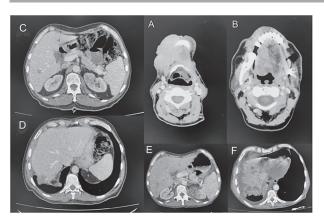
Computed tomography (CT) scans of the neck and chest
